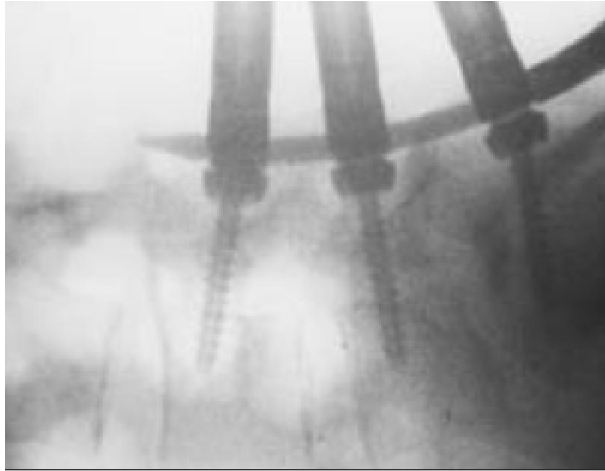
Intra-operative X-ray after insertion of the pedicle screws and the crossing rod percutaneously
